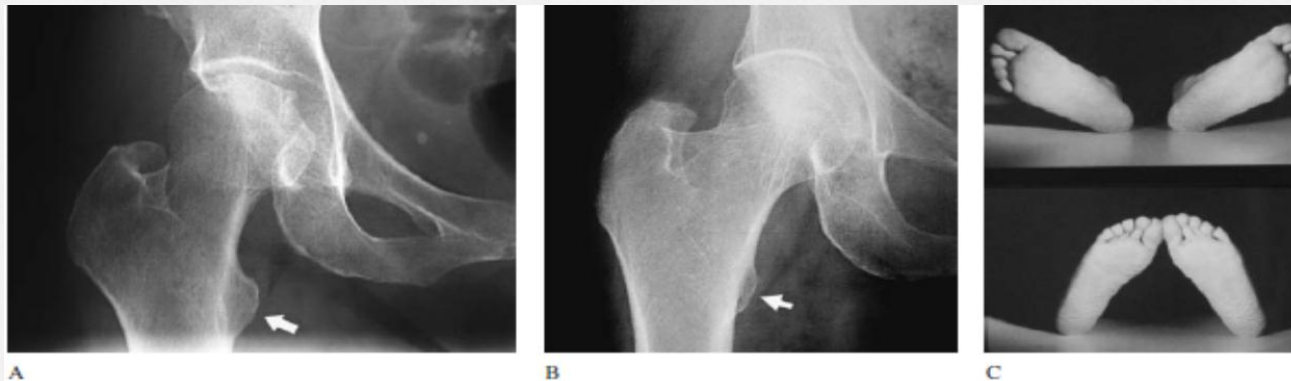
Positioning of the AP hip radiograph.
